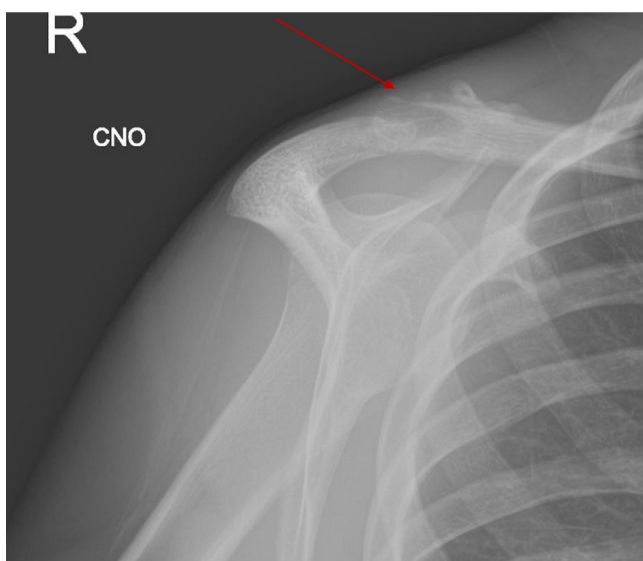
Radiograph 4 weeks post-injury.
